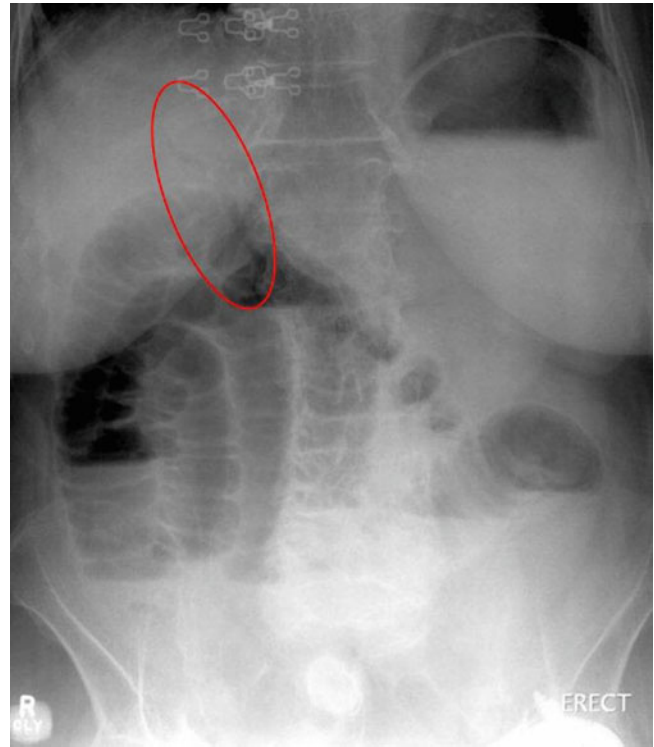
Plain abdominal radiograph of a patient with gallstone ileus. Note the presence of pneumobilia depicted in the *circled area*. Gallstones may not be present due to lack of calcium composition
